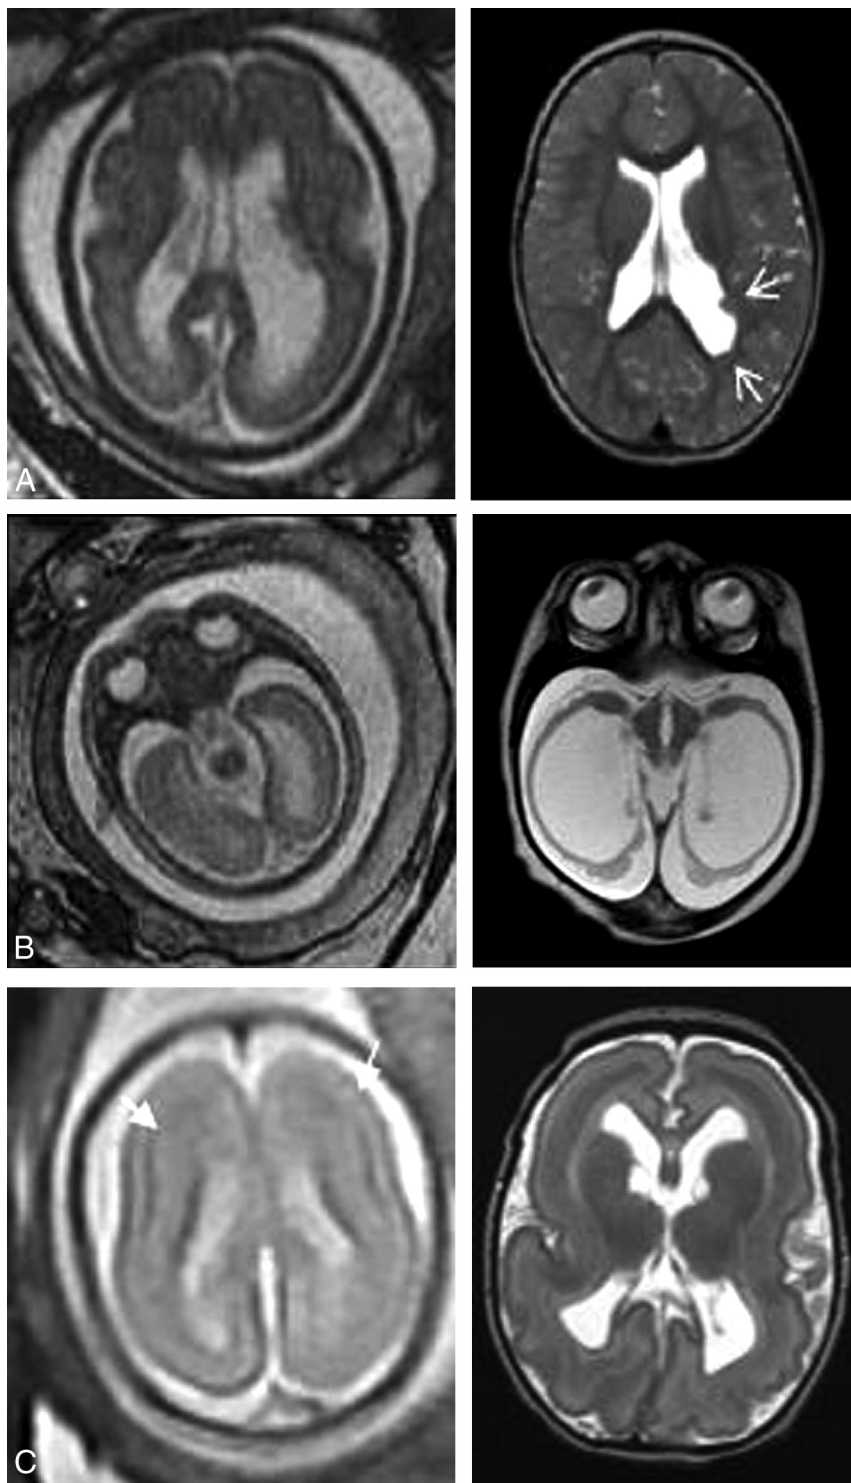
Prenatal and postnatal images showing examples of discordant imaging findings. A, Axial T2 feMRI at 27 weeks shows moderate VM, and postnatal axial T2 MRI shows mild VM with subependymal heterotopia (arrows). B, feMRI at 24 weeks shows mild VM and a preserved cerebral mantle, and postnatal MRI shows microcephaly and severe ventriculomegaly with thinning of the cerebral mantle. C, feMRI at 24 weeks shows a thin T2-hypointense cerebral line in the frontal lobes (arrows) that was overlooked. Postnatal MRI confirmed subcortical band heterotopia.
